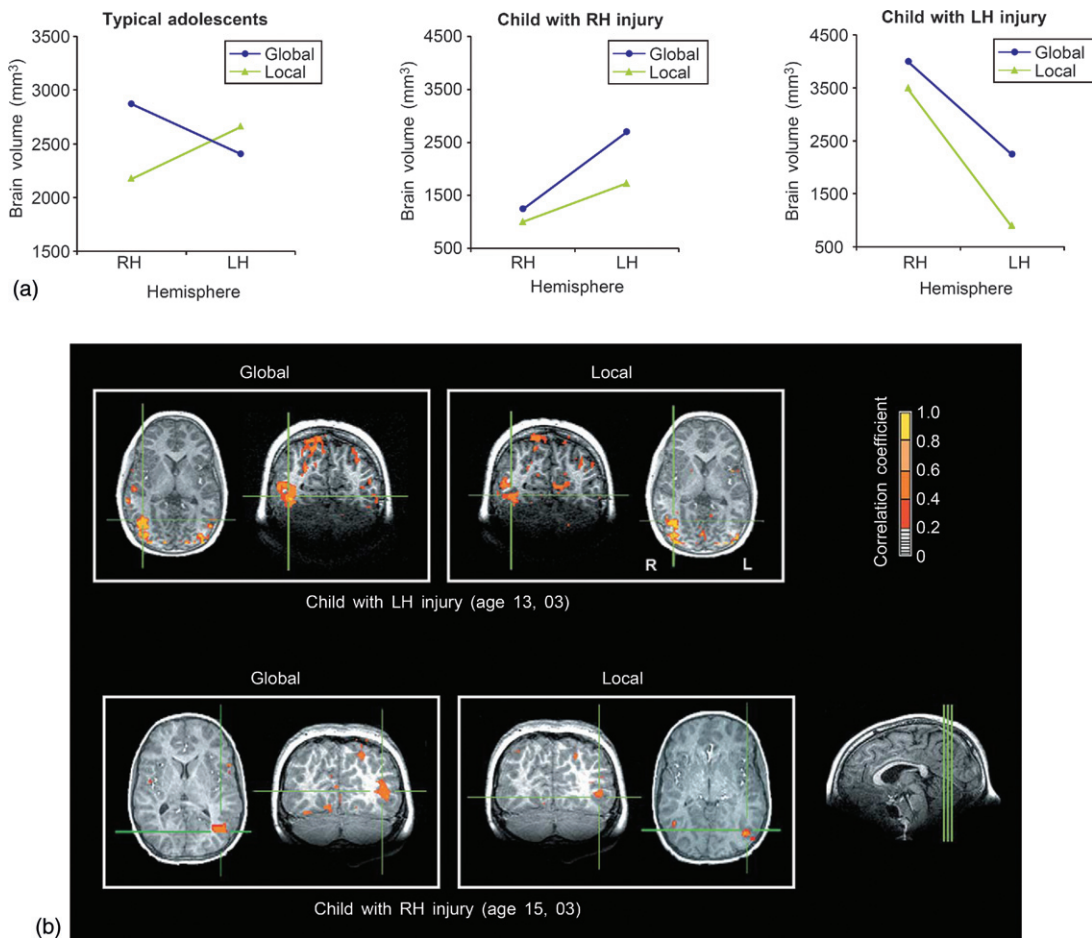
Global and local processing in the brain. Functional MRI activation data from two teenagers with prenatal focal brain injury on a hierarchical form-processing task, compared with data from typical adolescents. Each child participated in separate imaging runs, where they were asked to attend to either the global or the local level of the stimulus pattern. Unlike typical controls, who show different patterns of lateralization for global and local processing, the two children with lesions showed activation largely confined to the uninjured hemisphere. Activation images for the two children with perinatal brain injury are shown. Source: Adapted from Stiles et al., 2005, with permission.
